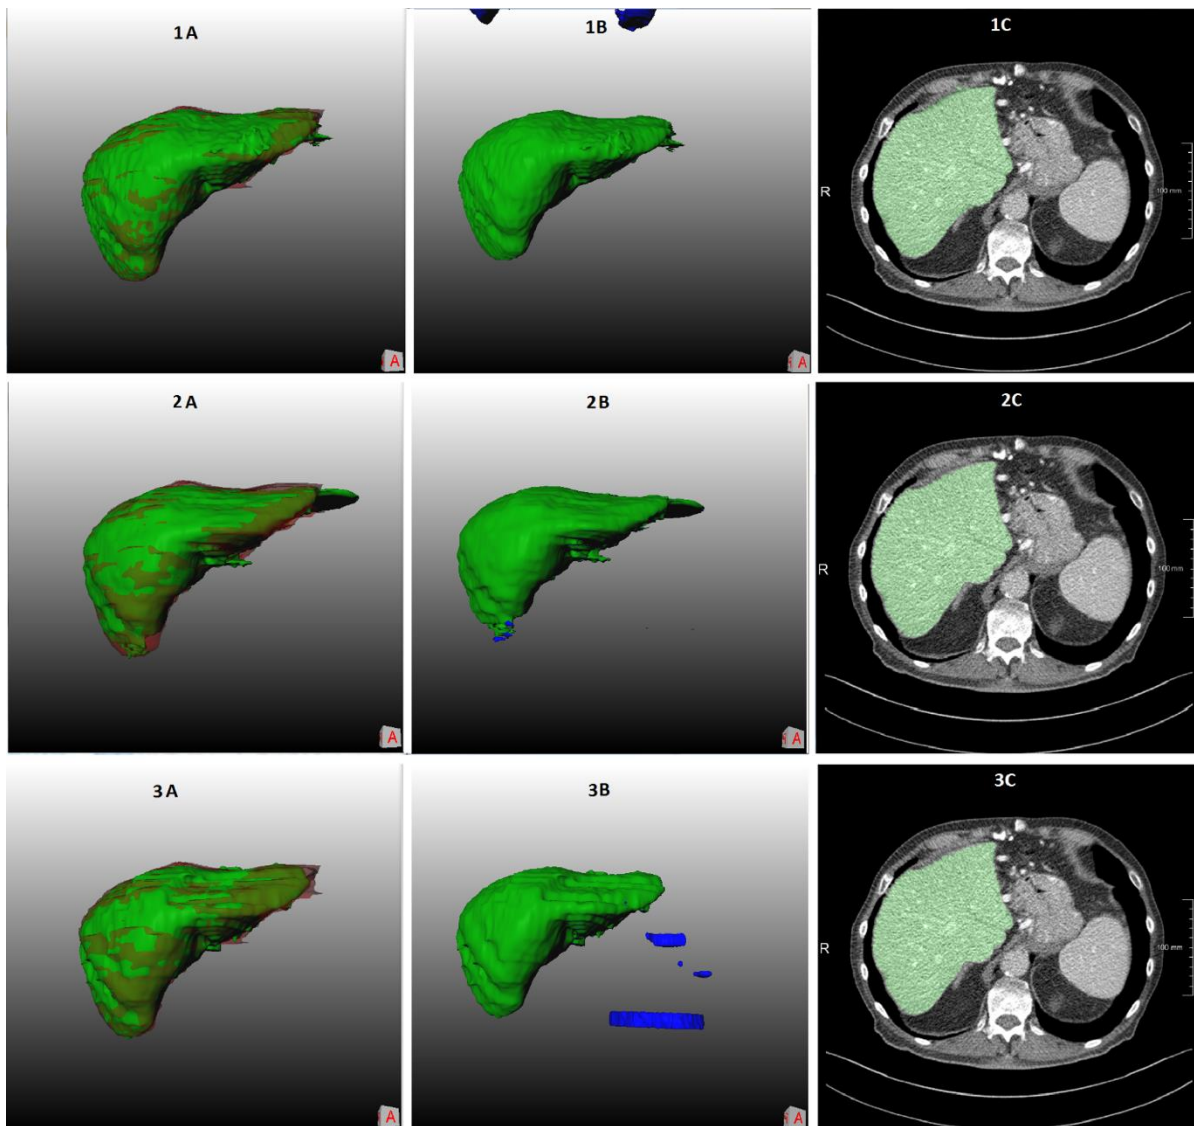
Example of 3D liver segmentations by the three CNNs on a low-dose contrast enhanced CT image.
